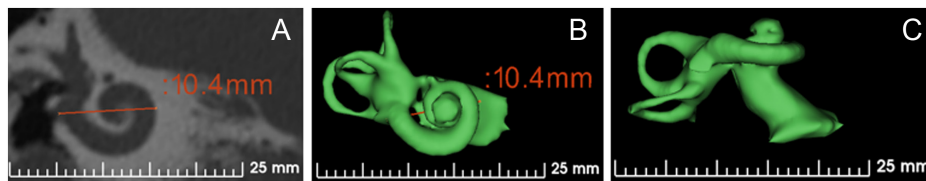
Computed tomography image of the cochlea in the oblique coronal plane showing the A-value measurement (A). Three-dimensional view of the cochlea in the oblique coronal plane (B) and axial plane (C).
